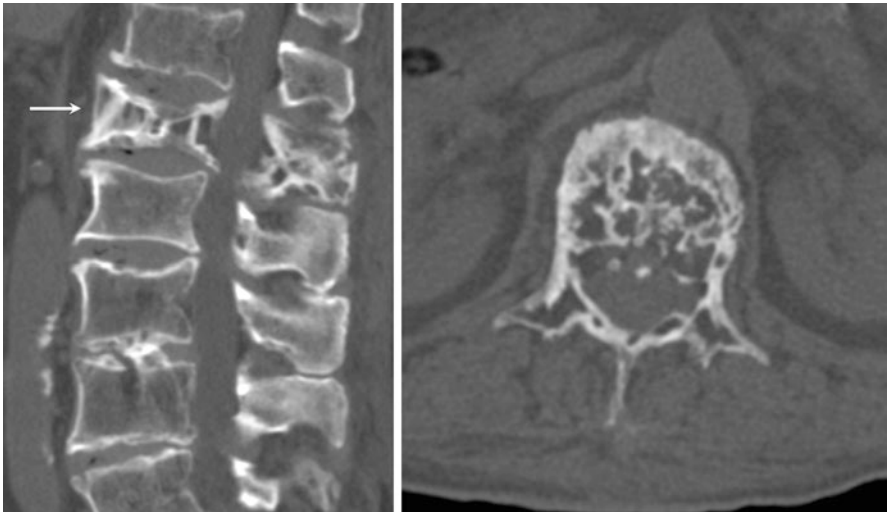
Sagittal and axial CT demonstrating osteolytic images of the L2 vertebral body and posterior elements during the initial phase
